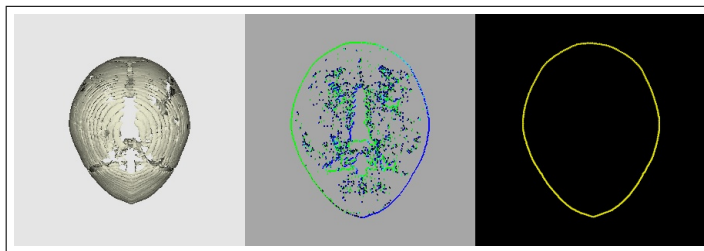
Extracting a 2D external contour (right) by first projecting the 3D surface mesh (left) onto a 2D plane (middle). Keeping only the exterior points from the silhouette. This approach allows processing and shape analysis to be done even on older CT scans that have noise and challenging imperfections.
